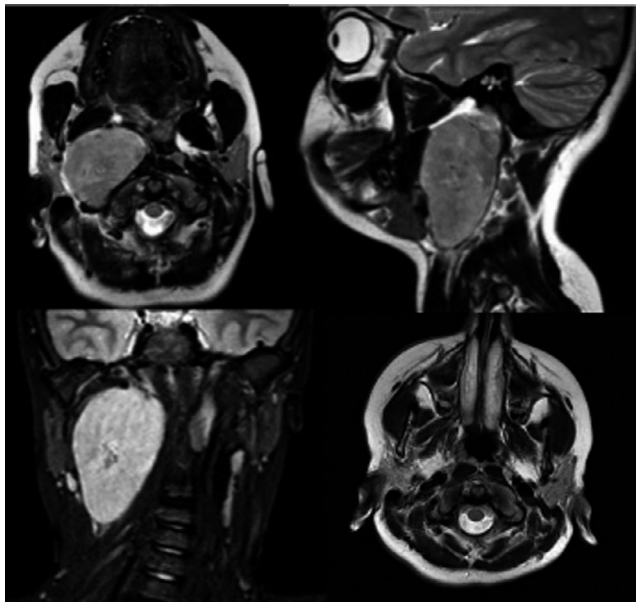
(A and B) T2-weighted MRI demonstrated a large ovoid mass in the right parapharyngeal space splaying the carotid artery and its branches and effacing the internal jugular vein. The tumor was heterogeneously hyperintense relative to skeletal muscle. (C) The lesion exhibits homogeneous avid enhancement after administration of gadolinium-based contrast, consistent with a radiologic diagnosis of schwannoma. (D) Imaging 6 months postoperatively demonstrates no evidence of disease
